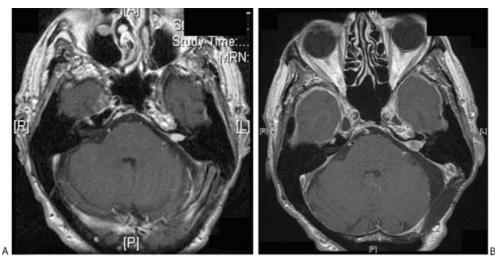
Serial magnetic resonance imaging scans of the patient. (A) December 1999. (B) December 2006 prior to pacemaker insertion.
